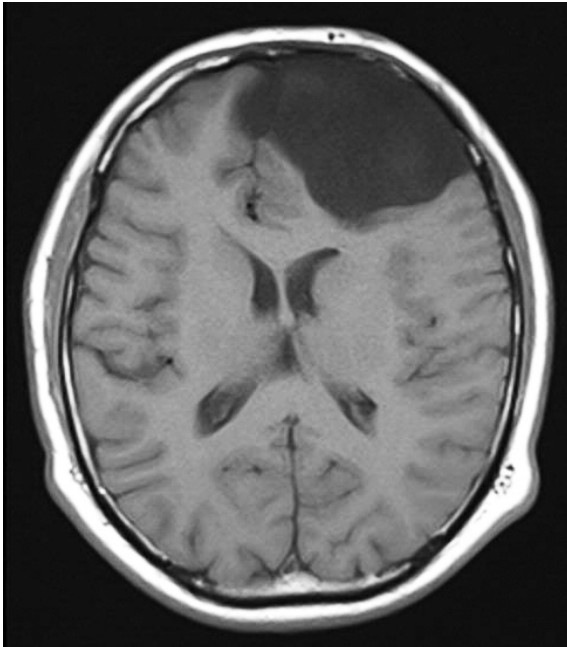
T1-weighted magnetic resonance image showed compression of the corpus callosum with a hypointense cystic lesion.
